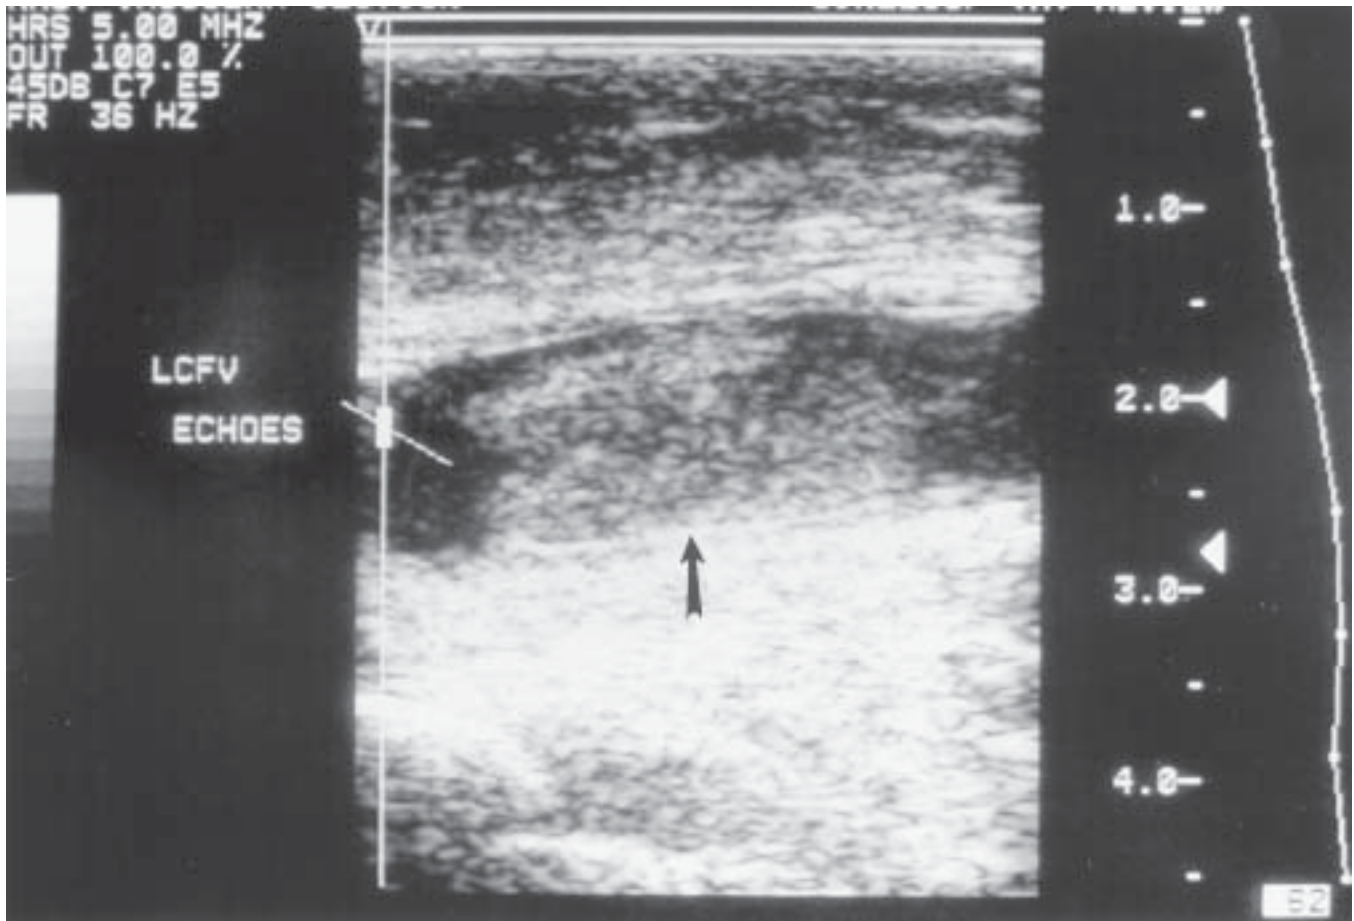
Intraluminal thrombus visualized with ultrasound (with permission).
